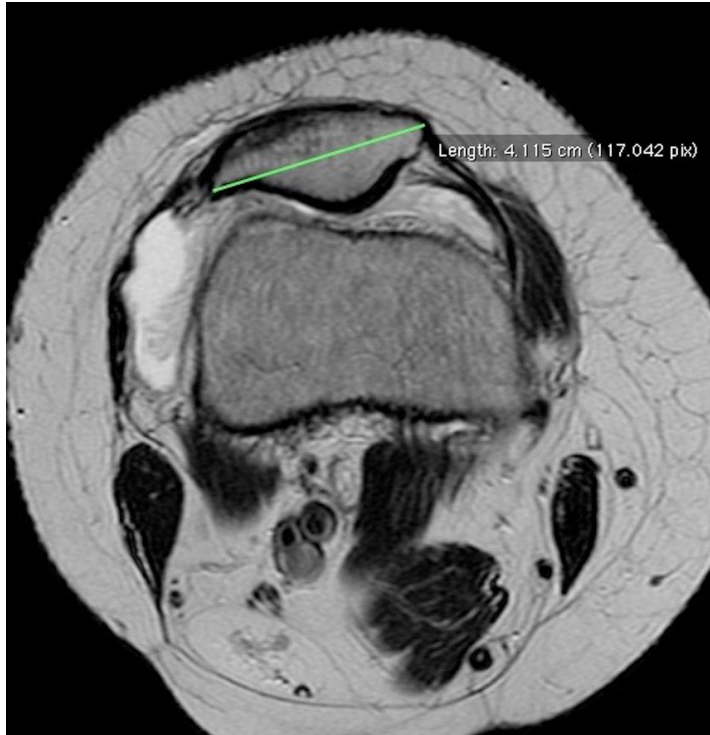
MRI measurement of the largest diameter of the patella.
